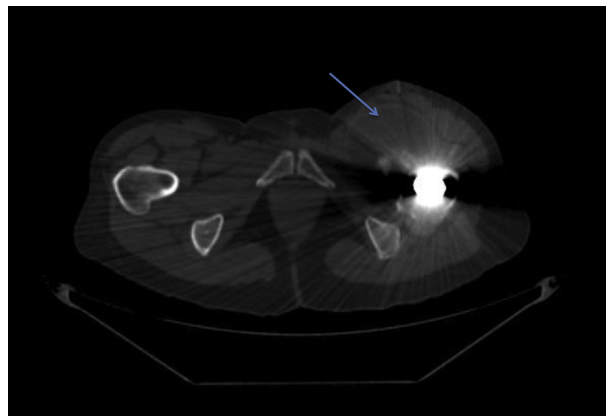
Axial computed tomography scan image demonstrating homogenous fluid collection in the anterior compartment of the left thigh (arrow).
